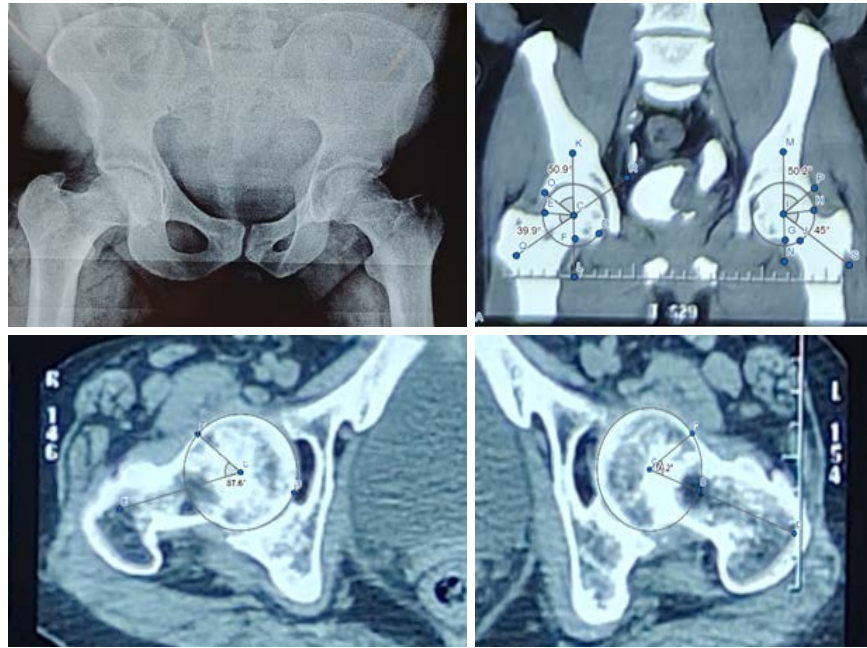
Bilateral mixed type of FAI confirmed by CT scan angle measurements of LCEA and alpha angles, showing evident pistol grip deformity in both hips of a 46-year-old male patient.
